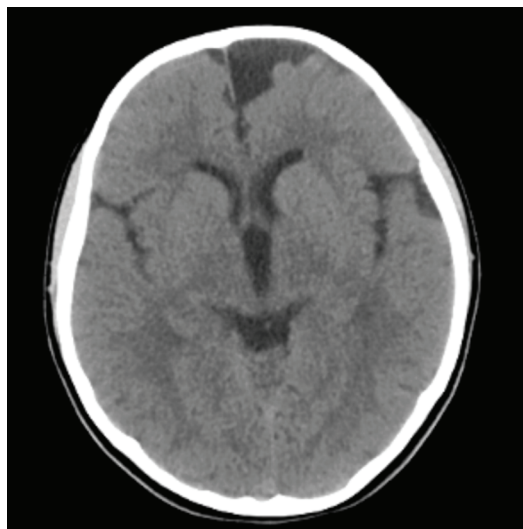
Arachnoid Cyst: Axial cranial CT: Small frontal arachnoid cyst anterior to the left frontal lobe
